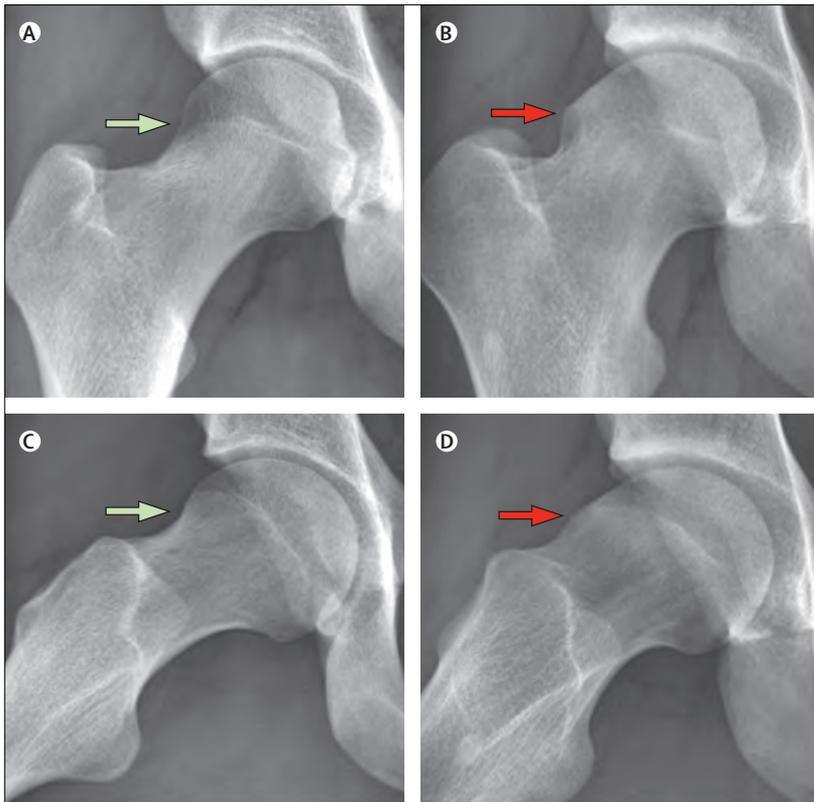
Anteroposterior and lateral radiographs of a normal hip (A and C) and a hip with cam lesion femoroacetabular impingement morphology (B and D)
